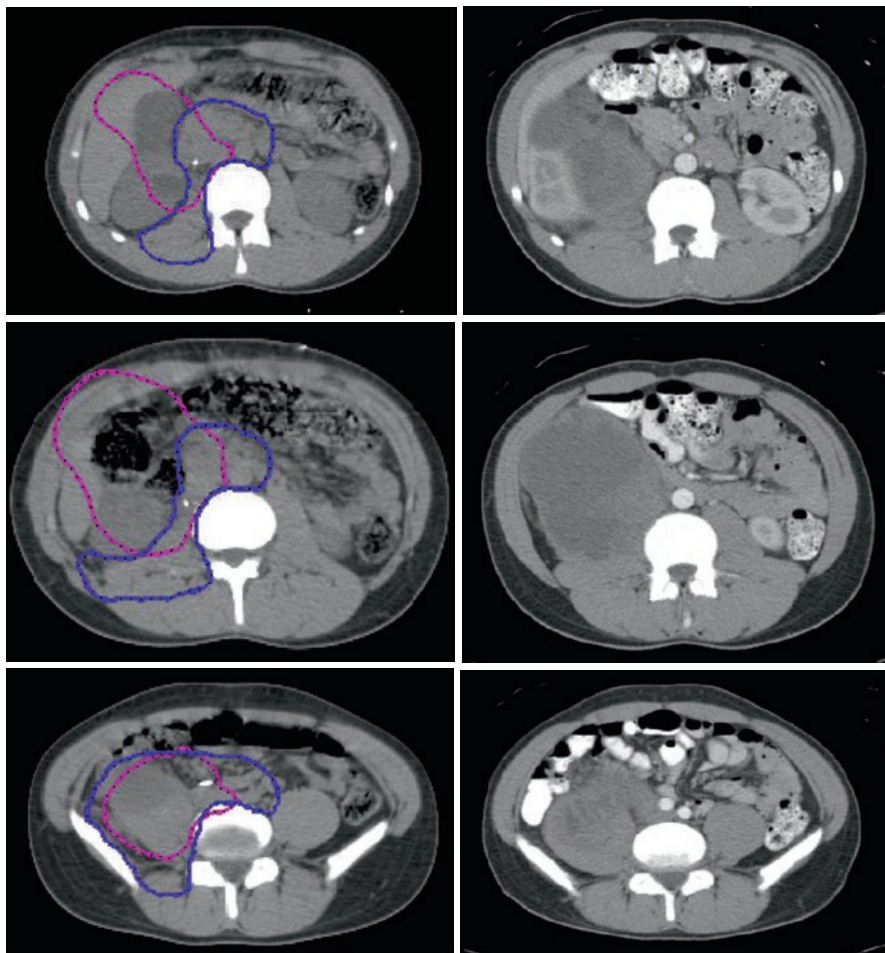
Preoperative CT scan of a high-grade retroperitoneal NRSTS. The patient underwent resection with 1 mm surgical margins. Postoperative radiation therapy was delivered to two volumes: 45 Gy to the initial tumor volume and a boost of 55.8 Gy to areas of close surgical margins
